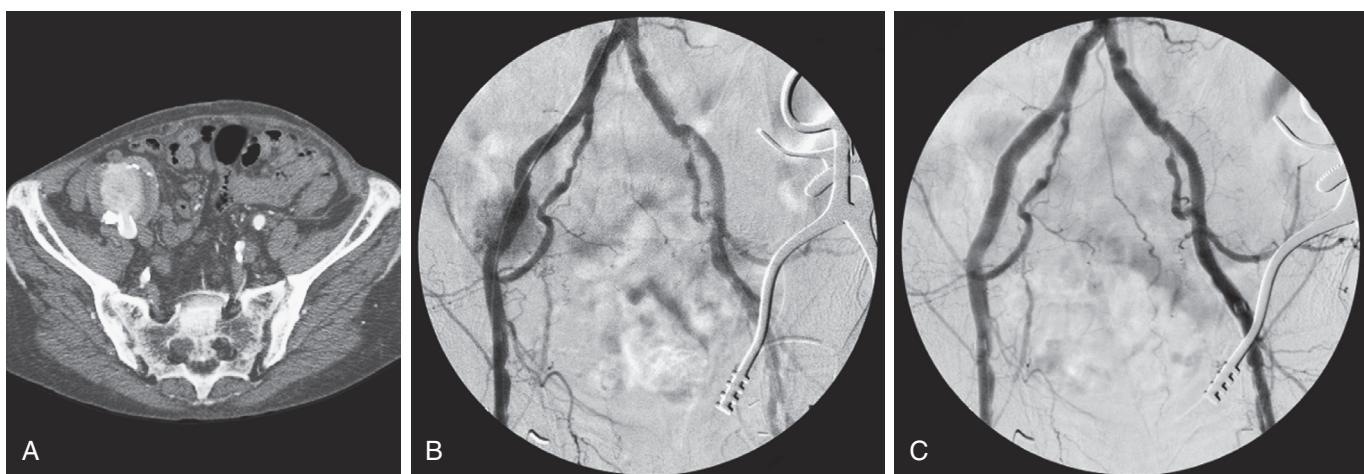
(A) Axial computed tomography of a right external iliac anastomotic aneurysm. (B) Diagnostic arteriogram demonstrating a right external iliac anastomotic aneurysm. (C) Successful exclusion of the external iliac anastomotic aneurysm with a covered stent.
